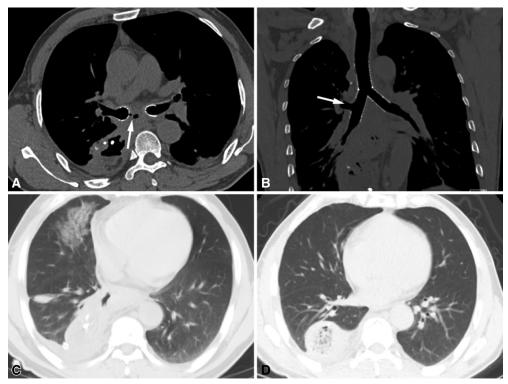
A, Axial CT image obtained after stenting showed that the fistula was completely sealed (*white arrow*). B, Coronal CT after stenting showed that the stent was in place. The fenestration of the right branch of the stent fitted well to the opening of the right upper lobe bronchus (*white arrow*). C, Axial CT image before stenting showed pneumonia in the patient. D, Axial CT image 52 days after stenting showed that the pneumonia was absorbed.
